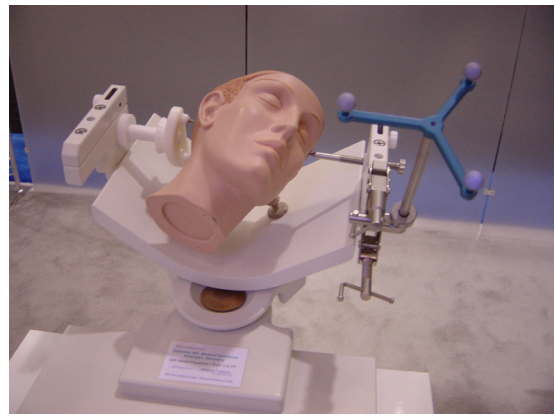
The Noras 8-channel OR head coil (Noras MRI products GmgH, Germany), used both as a head holder and as a head coil for intraoperative MRI.
